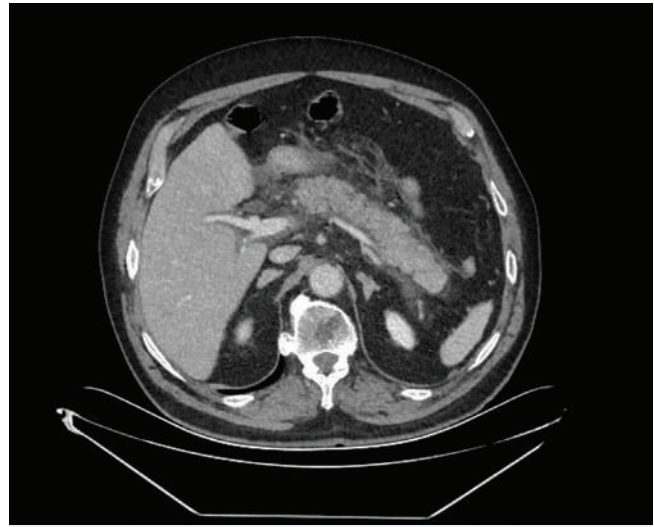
Contrast-enhanced abdominal CT demonstrating a bulky appearance of the pancreas and inflammatory changes in the peripancreatic fat planes; findings consistent with acute pancreatitis.
